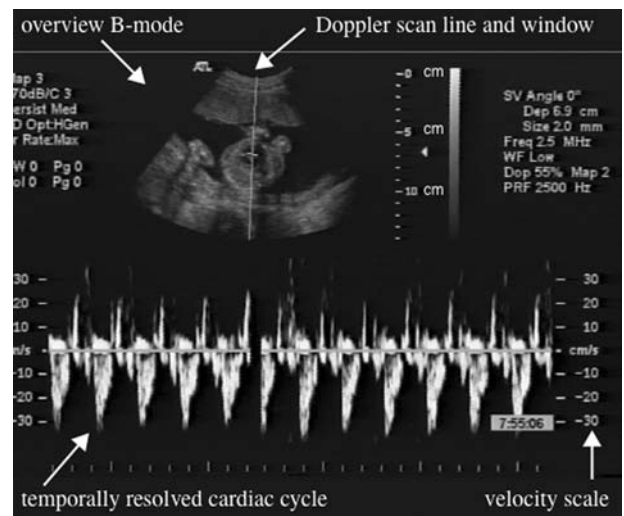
Pulse wave Doppler example. See text for more description.
